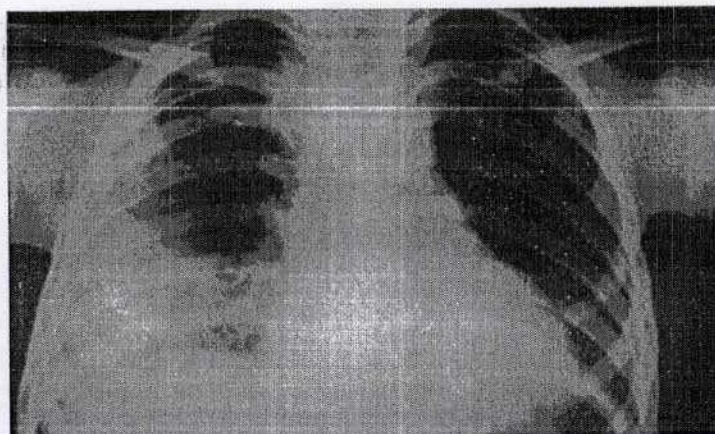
X-ray chest right lower lobe pneumonitis with cardiac border cut off sign
